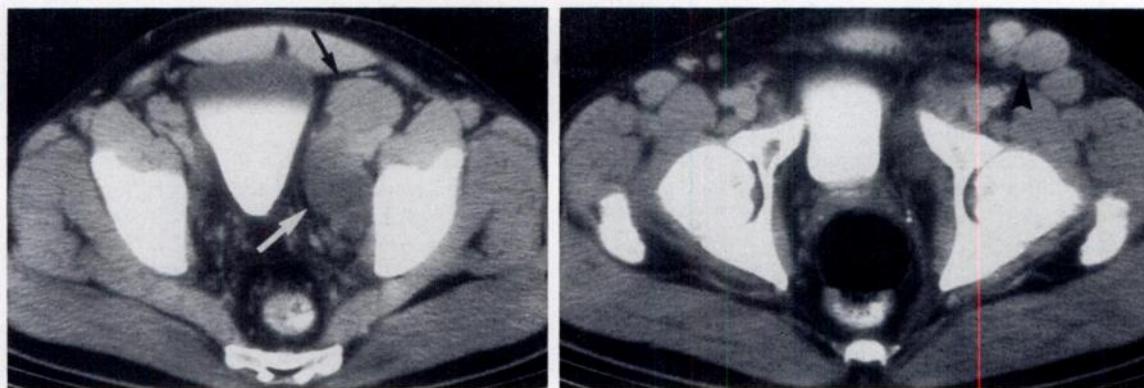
CT scans obtained at two different levels in a 46-year-old patient with lymphoma show marked enlargement of the left external iliac (black arrow in a), left obturator (white arrow in a), and inguinal (arrowhead in b) nodes.
